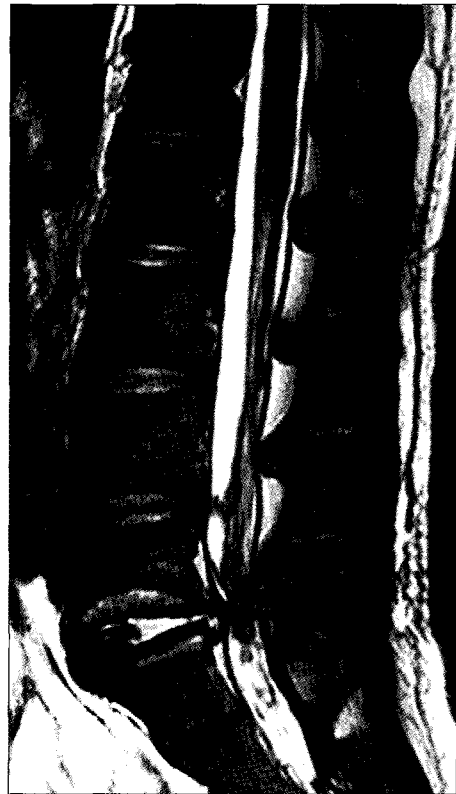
T2-weighted MRI 1 week later after surgery shows well-decompressed herniated disc and total excision of cystic mass.
